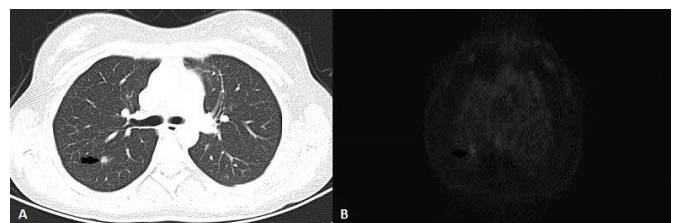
Solid nodule with peripheral ground-glass opacities in the lower lobe superior segment of the right lung is seen. A) Axial CT imaging B) Axial fluoro-18 fluorodeoxyglucose-positron emission tomography imaging
